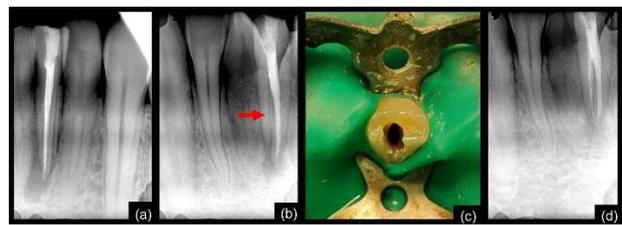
(A) Postoperative periapical radiograph showing obturation of 31. (B) Periapical radiograph taken by shifting the cone mesially reveals the missed lingual canal in relation to 31 (arrow representing the missed lingual canal). (C) Clinical picture of 31 with widened access opening to gain straight-line access to the lingual canal. (D) Postoperative periapical radiograph showing obturation of both the canals in relation to 31.
